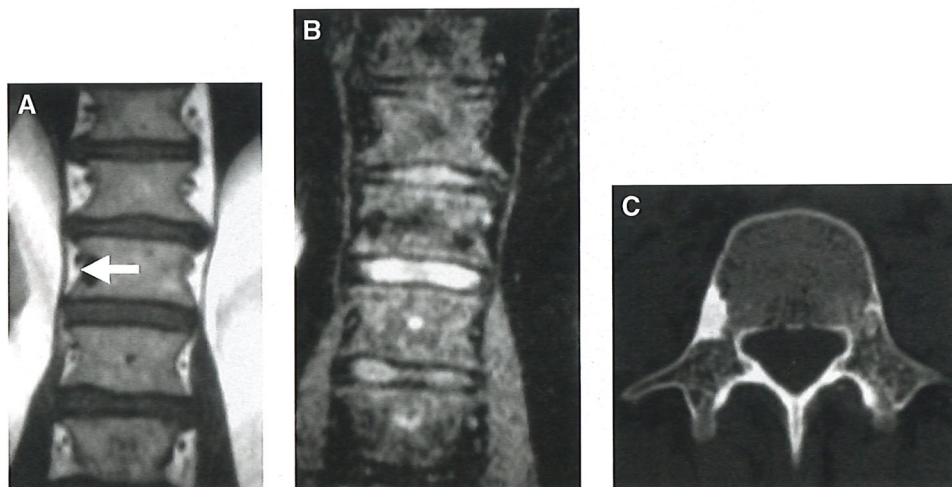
Typical vertebral enostosis. (A) Coronal T1-weighted and (B) STIR images show an area of very low signal intensity in the right aspect of the vertebral body (arrow). (C) Axial CT image of that vertebral body shows a typical bone island, adjacent to the vertebral wall.
